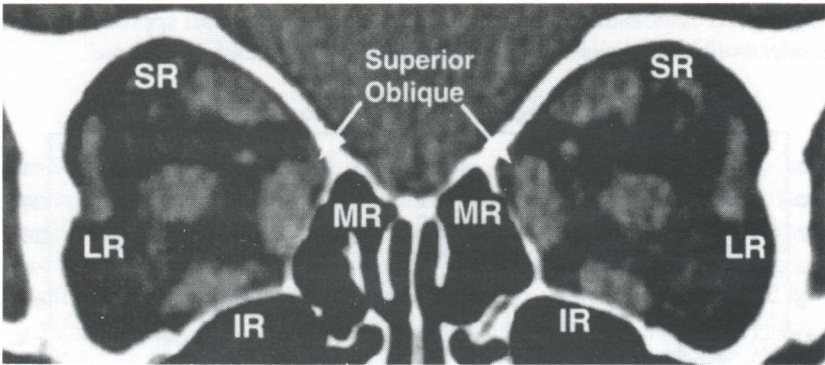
CT scan of 6 year old girl with "A" pattern esotropia  $60\Delta$  greater in elevation than depression. Note LR displaced superiorly and SR displaced nasally in both eyes.
